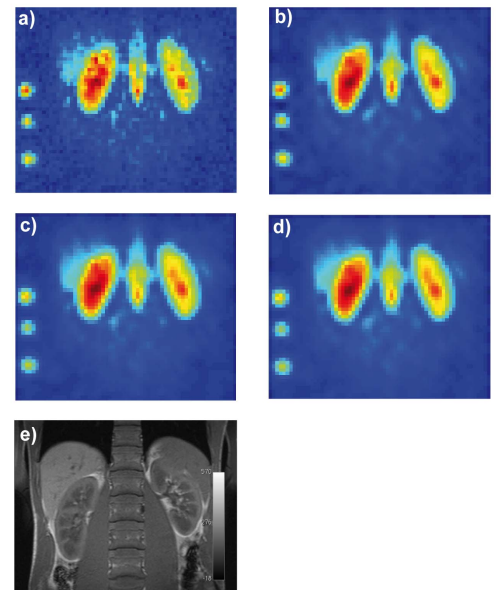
Results of applying optimal parameterized filters to ²³Na MR images. a) Original image, b) Gaussian filtered image, c) Hamming filtered image, d) Fermi filtered image, and e) T1-weighted morphological image as reference. Colors refer to intensity values of ²³Na, high signals are depicted in red.
